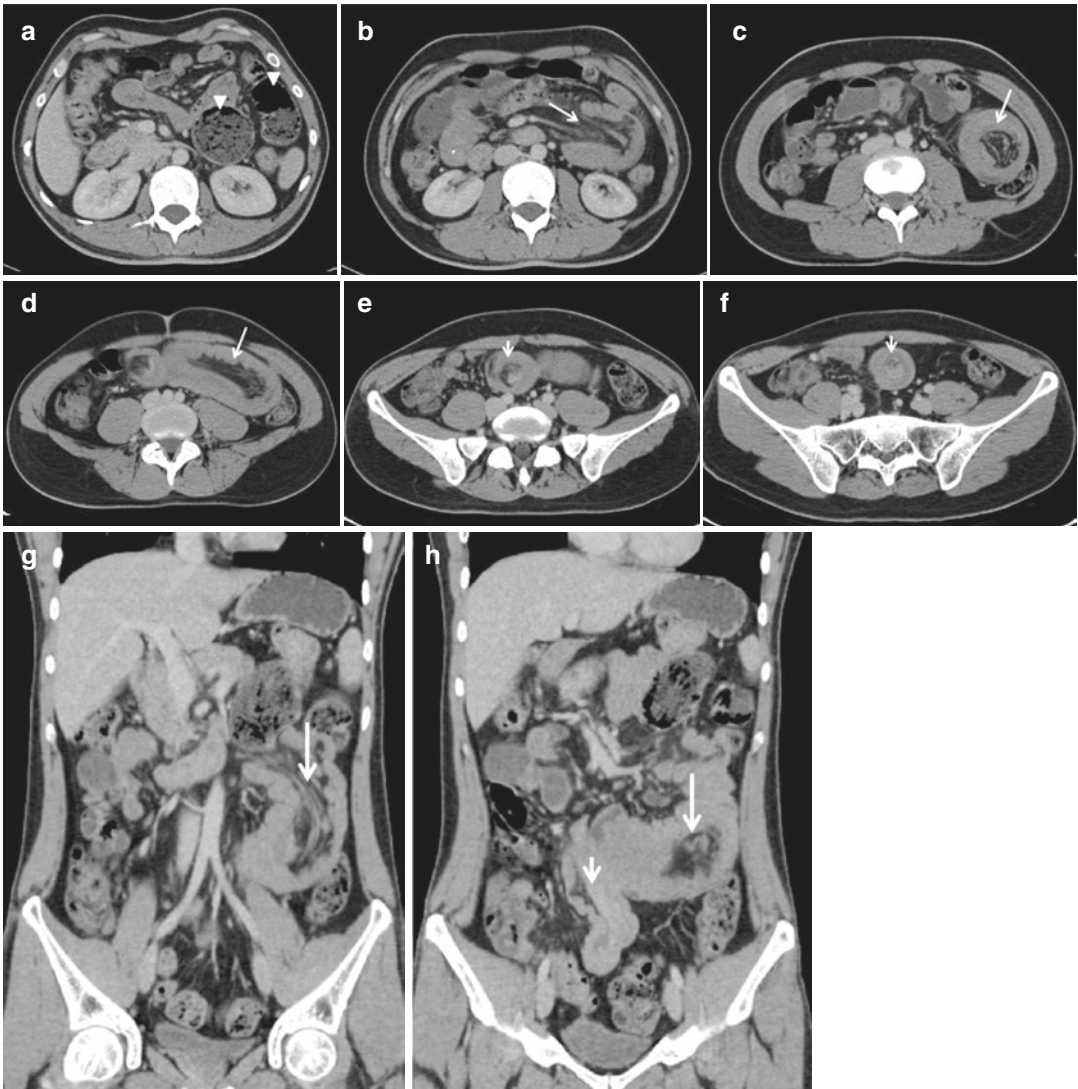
Transverse (a–f) and coronal-reformatted (g–h) CT images of a 28 years old man with Peutz-Jeghers syndrome. Jejunal (long arrows) and ileal (short arrows)
